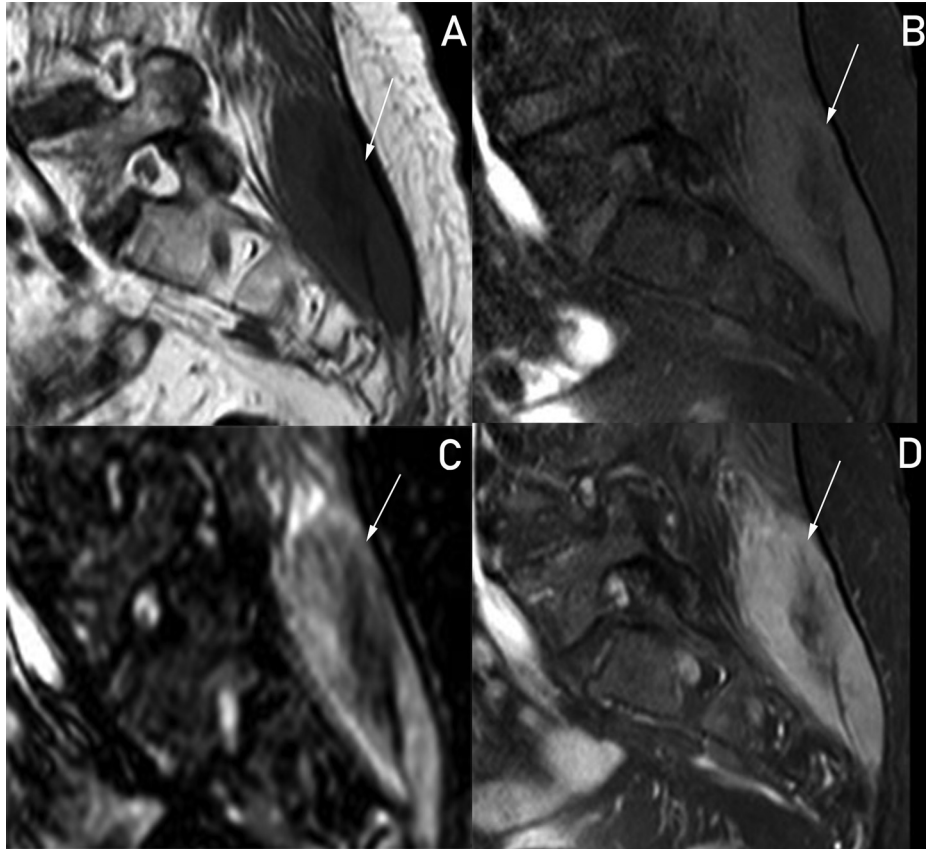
(A–D). Sagittal MRI show the intramuscular location of the mass. (A) An sagittal T1WI image shows the tumor with a signal isointense to the skeletal muscle (B) The mass shows a hyperintense heterogeneous signal intensity on T2-weighted sequences, is (C) isointense to skeletal muscle on T1-weighted fat-saturated images, and (D) shows obvious heterogeneous enhancement with contrast.
